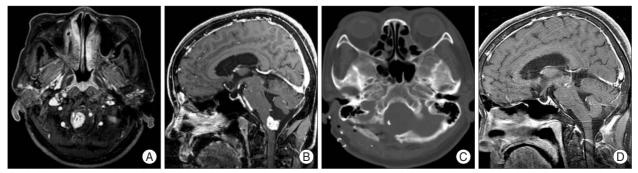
Pre- and postoperative radiological findings in accessory nerve schwannoma. Preoperative MRI showed a 2.5 × 3 cm sized heterogenous enhancing mass in cervicomedullary junction (A and B). Postoperative CT scan showed evidence of right suboccipital craniotomy (C). There was no recurrence during 3 years after surgery (D).
